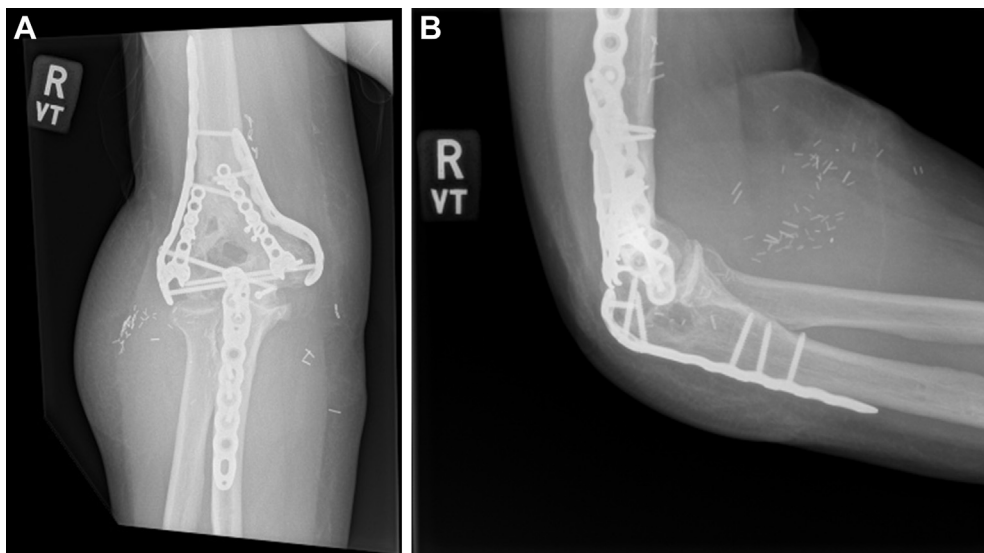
(A) Anteroposterior radiograph of right elbow at 1 year. (B) Lateral radiograph of right elbow at 1 year.
